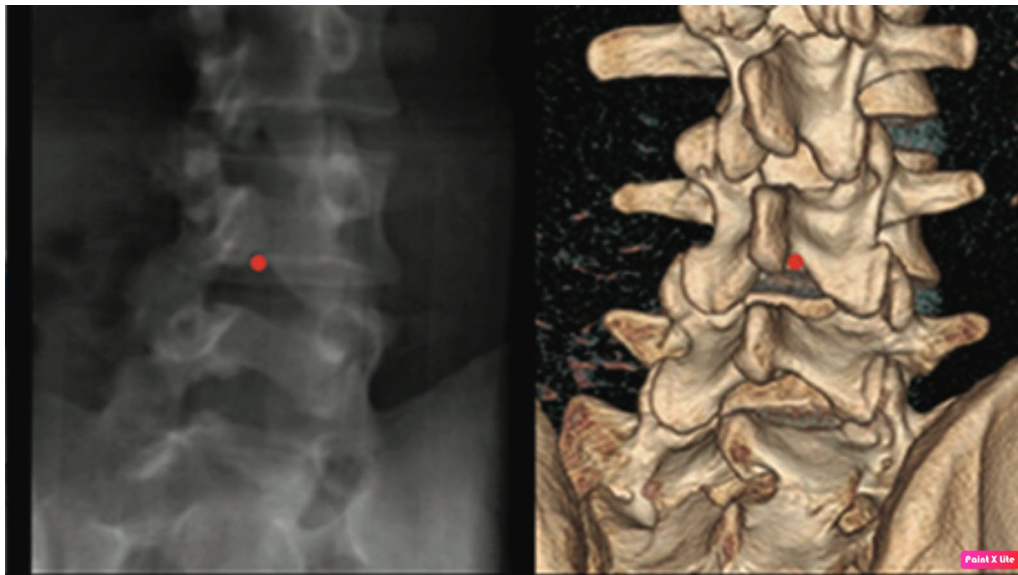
Fluoroscopic view (left) and 3D lumbar CT (right) of the interlaminar access after slightly tilting the imaging unit in CC and RL axes to open up the L4/5 interlaminar space. The inferior border of the lamina at spinolaminar junction is targeted. (Reproduced from [59])
